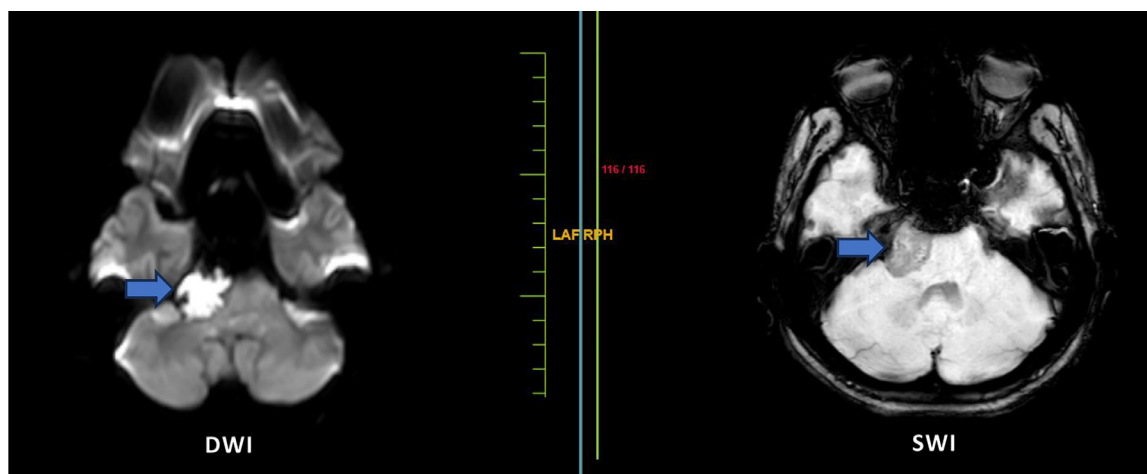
MRI Brain Axial sections – Lesion in right cerebellopontine (CP) angle shows restriction on DWI and no blooming on SWI.
